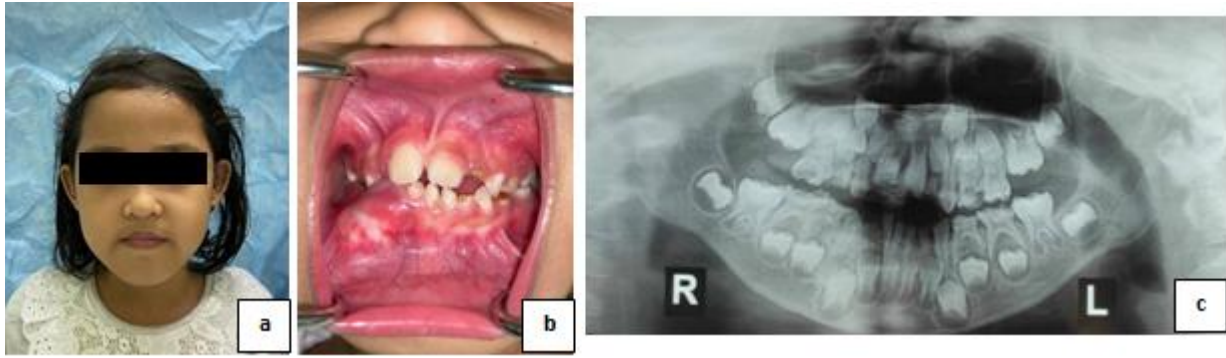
(a) Extraoral and (b) intraoral findings and (c) panoramic x-ray was obtained
